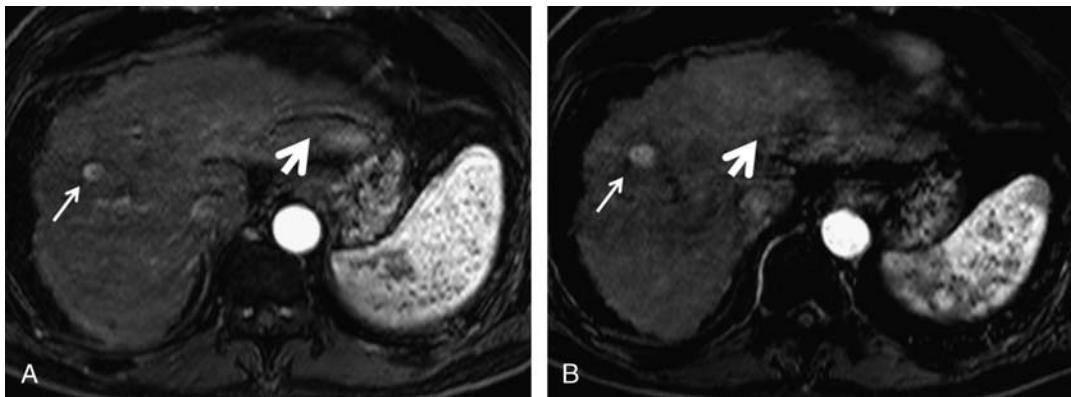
A 63-year-old man with chronic liver disease caused by hepatitis C virus infection and HCC, who was scanned with the bolus-tracking and test-bolus protocols. A, A 3D T1-weighted GRE sequence with fat-suppression image, clearly showing a hypervascular HCC (thick arrow), as well as a slight artifact (thin arrow) in the HAP image with the bolus-tracking method. B, This artifact is inconspicuous in the HAP image with the test-bolus method.
